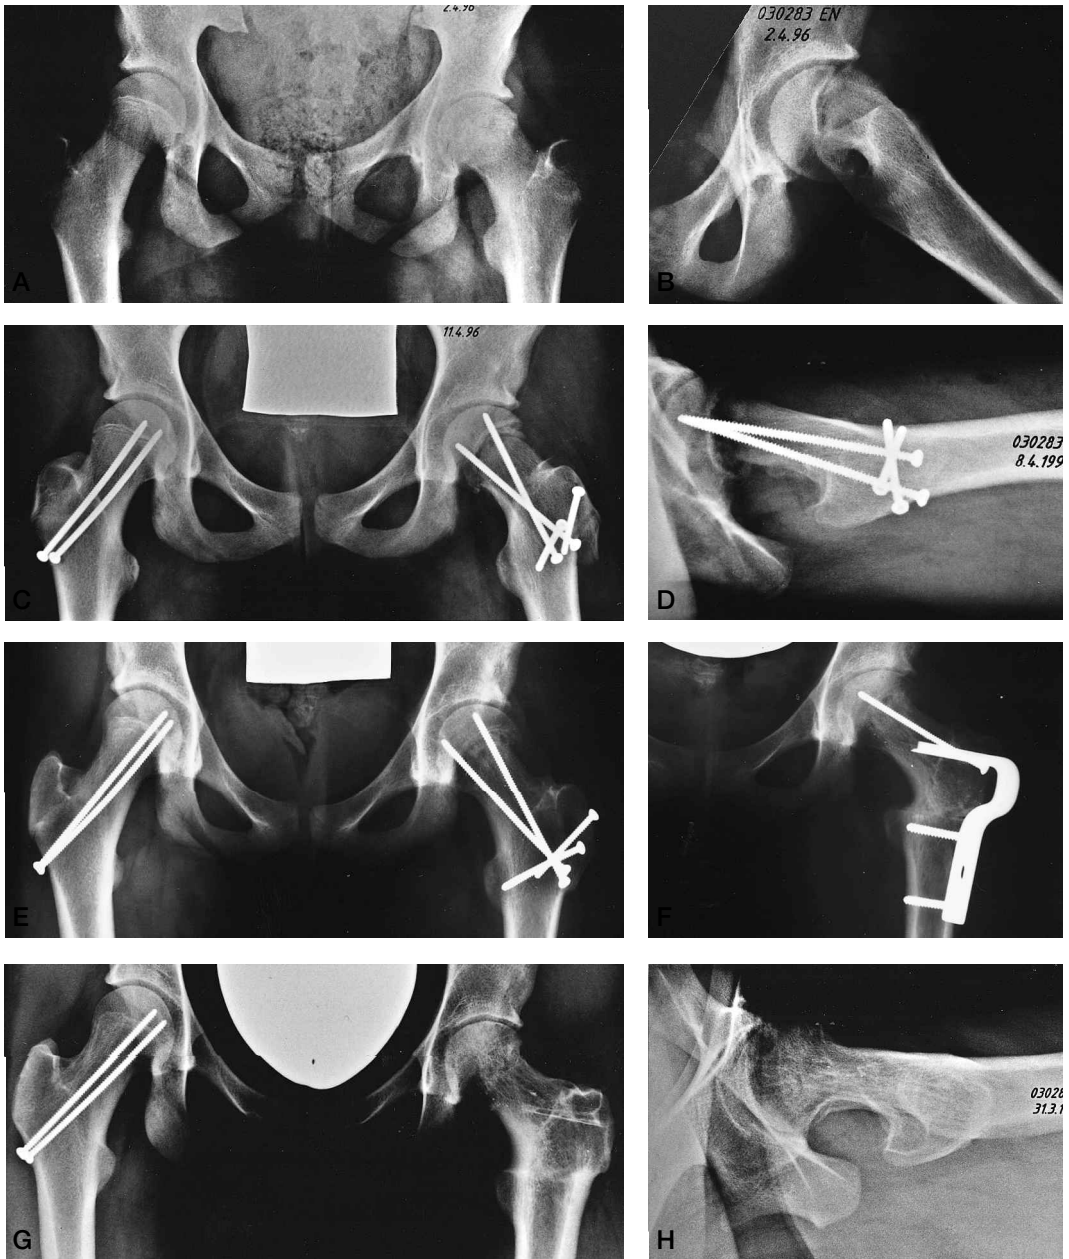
(A) Anteroposterior and (B) lateral radiographs 6 months after the initial development of pain in the left hip. An acute-on-chronic SCFE was present with a posterior slip of  $60^\circ$ . Postoperative (C) anteroposterior and (D) lateral radiographs after a subcapital osteotomy and callus resection. The joint remained non-concentric (even after institution of spica treatment in slight abduction and flexion) (E). At 4 months, a varus-extension intertrochanteric osteotomy was performed. Anteroposterior (G) and lateral radiographs (H) 3 years after surgery show an almost normal joint space, but signs of prearthrosis.
